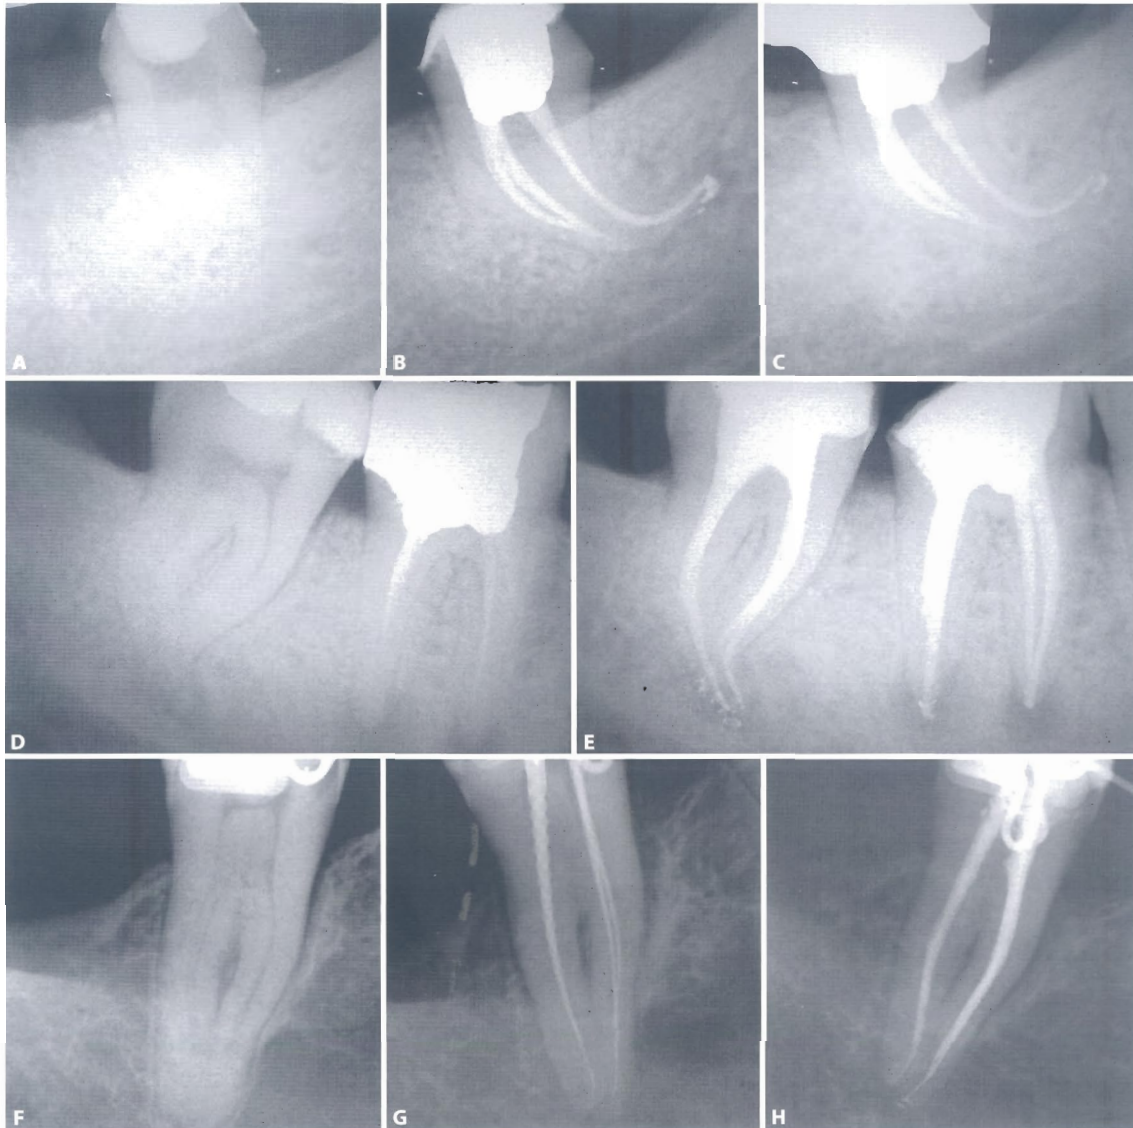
Clinical cases of teeth with very accentuated canal curvatures. In these cases it is important to use NiTi rotary instruments with low taper to prevent fracture due to cyclical fatigue. A. Preoperative radiograph of a lower left third molar. B. Postoperative radiograph. C. Follow up radiograph after one year (E. Berutti). D. Preoperative radiograph of a lower right second molar. E. Postoperative radiograph (E. Berutti). F. Preoperative radiograph of a lower right second molar. G. Radiograph to check the working length of the mesial canals and the distal canal. H. Postoperative radiograph (G. Cantatore).
